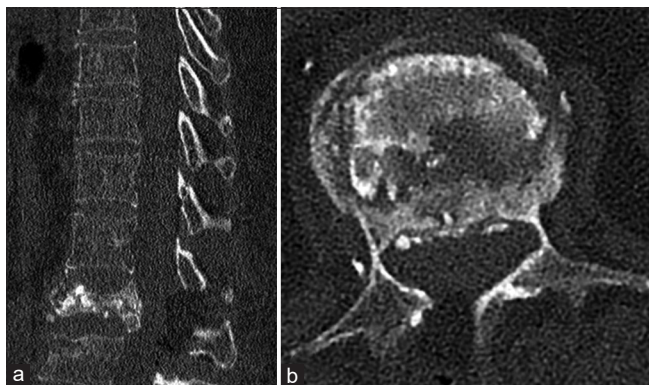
Post-operative thoracolumbar sagittal (a) and axial (b) computed tomography sections.
